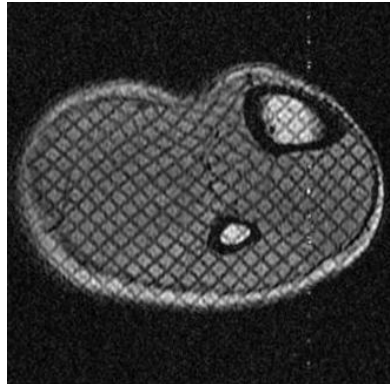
Frame 7 of tagged MR image of human lower leg
